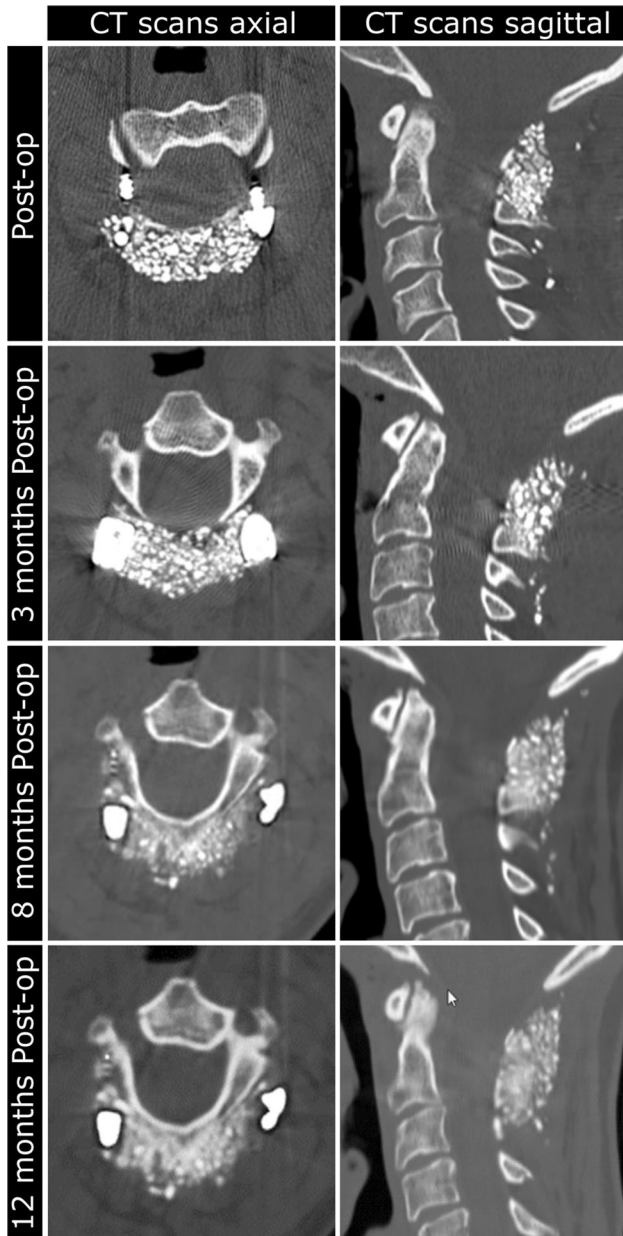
Post-surgery CT scans of laminectomy with C1–C2 posterior fusion using a mixed of local bone and GlassBone
